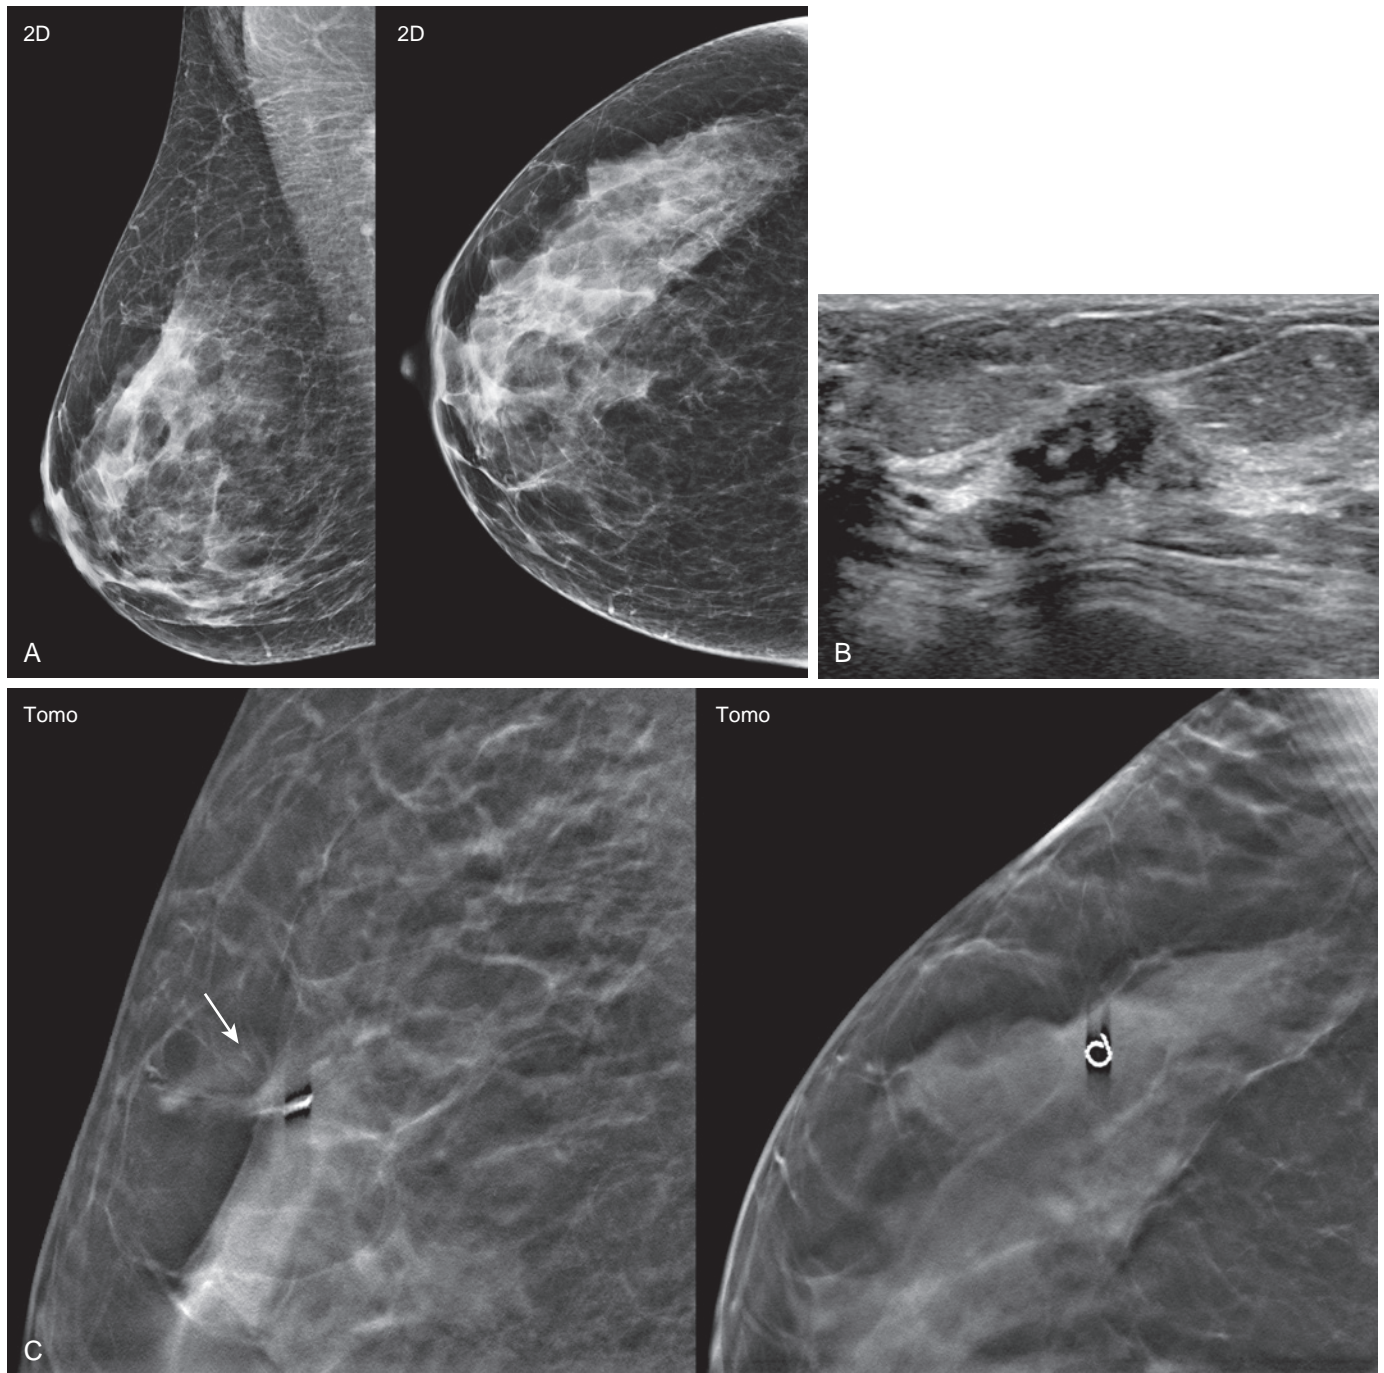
Tomosynthesis occult cancer. (A) A 51-year-old woman had a normal tomosynthesis screening mammogram (right breast 2D images shown). (B) Screening ultrasound performed 1 month later revealed an irregular hypoechoic 1 cm mass in the upper outer quadrant. Ultrasound-guided biopsy revealed invasive ductal carcinoma, well-differentiated, ER/PR+, Her2–, 0 SLN. (C) Post-biopsy tomosynthesis spot views in MLO and CC show biopsy marker in an area of dense tissue with subtle spiculation (*arrow*), not obvious prospectively, even on tomosynthesis.
